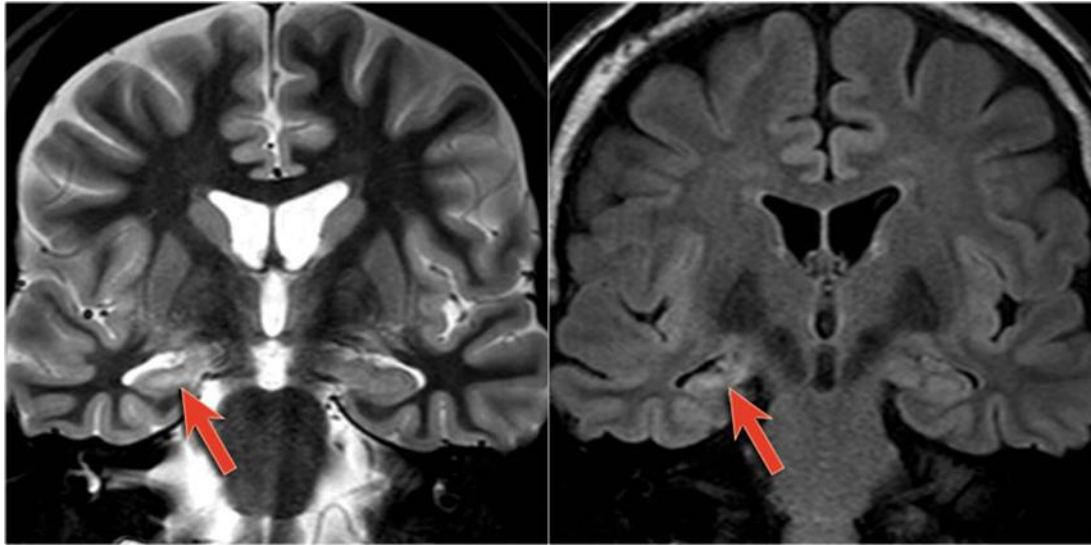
The coronal T2WI and FLAIR images show right-sided mesial temporal sclerosis.
